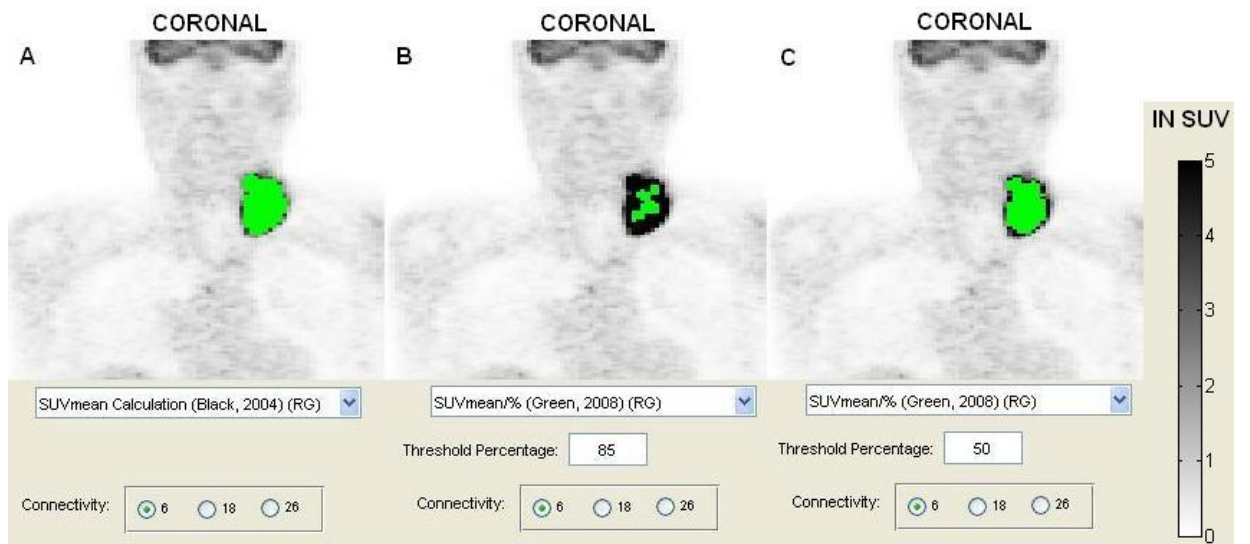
Visual Display of Region Growing Segmentations using SUV_{mean}
